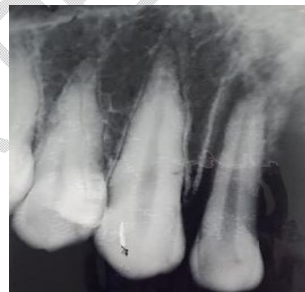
Initial Radiograph of 12
